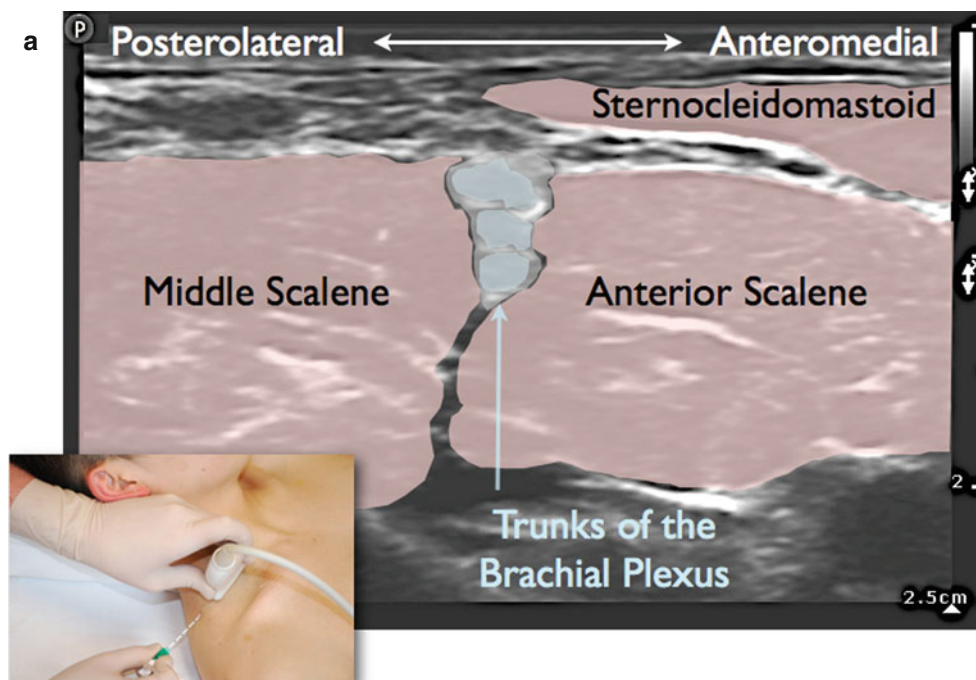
(a) Transducer position and corresponding sonogram for the interscalene approach to the brachial plexus. (b) Transducer position and corresponding sonogram for the supraclavicular approach to the brachial plexus. (c) The great vessels of the neck can be used as a readily
